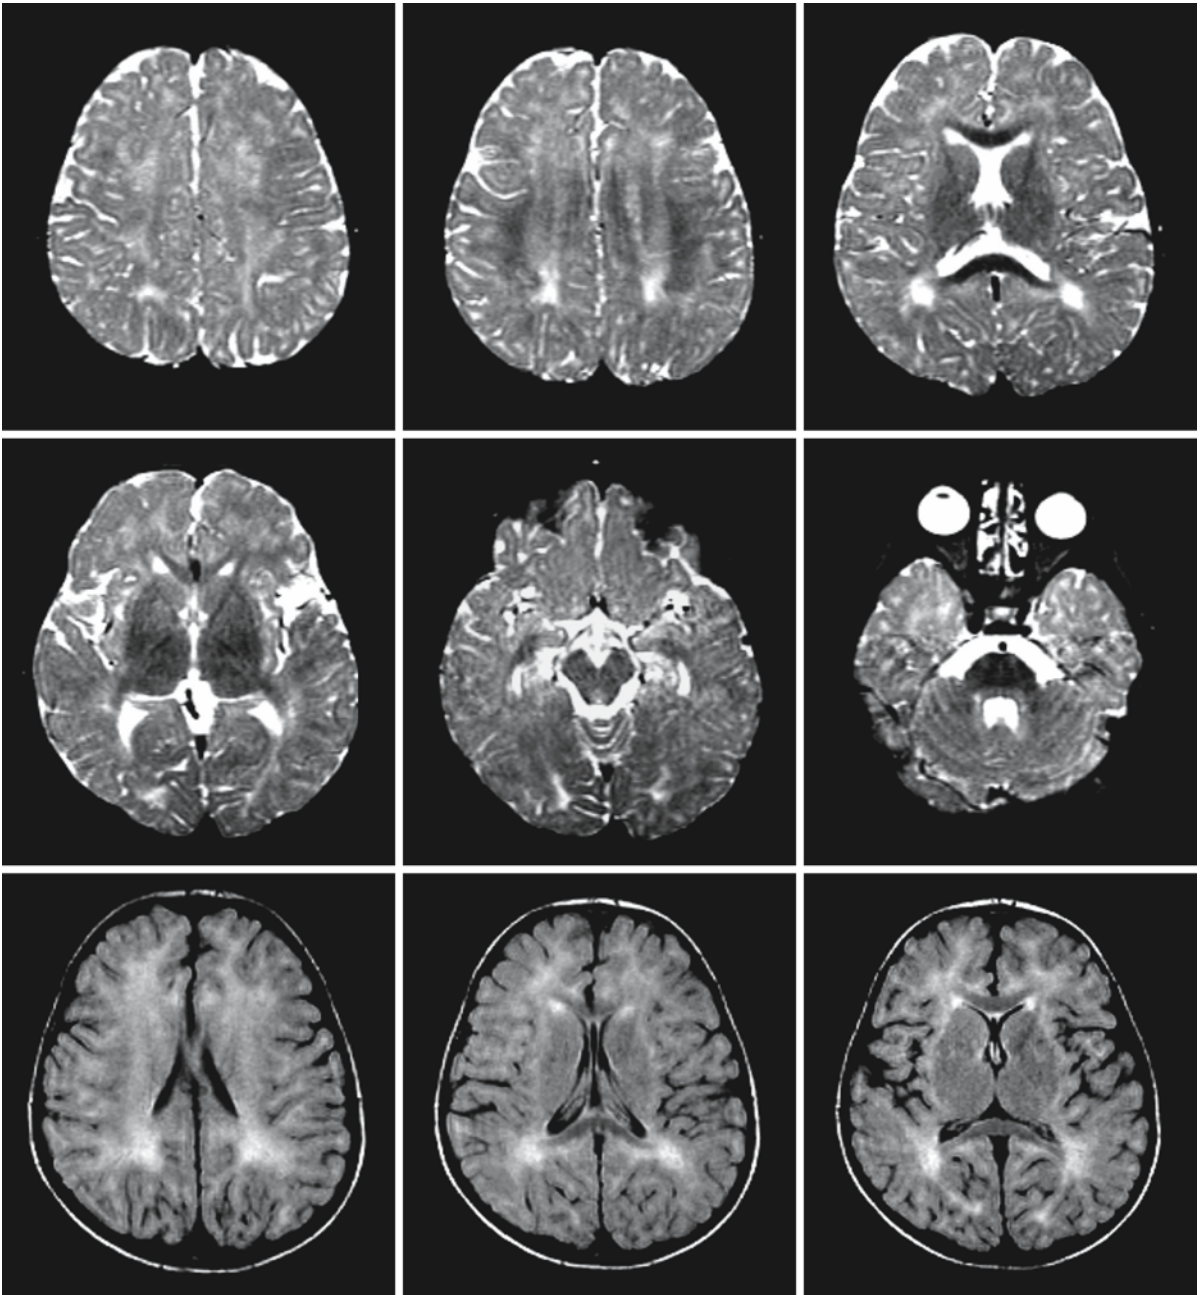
A 4-year-old boy with galactosemia type 1. Note the seriously delayed myelination. In addition, the T_2 -weighted images show foci of elevated signal intensity in the periventricular region, most marked posteriorly. The FLAIR images (*third row*) confirm the white matter abnormalities
